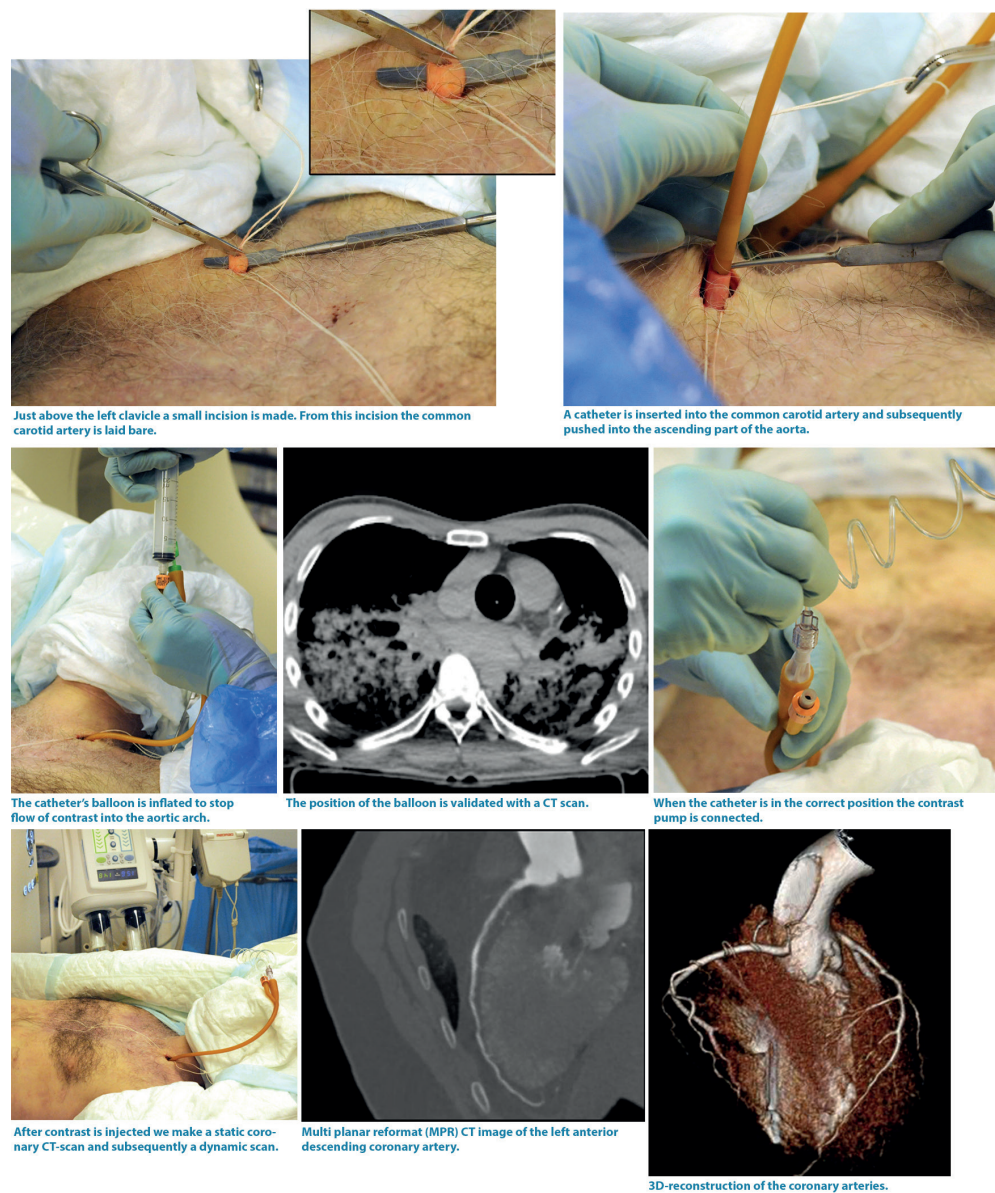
Coronary CTA with local administration of contrast agent
